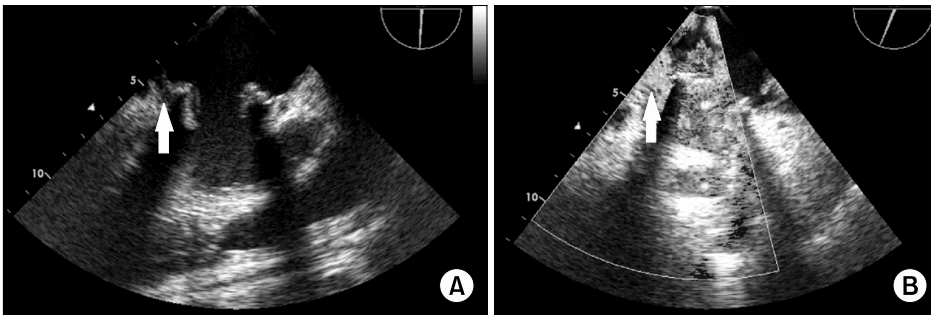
Transesophageal echocardiography shows prosthetic valve dehiscence. (A) 2-D image, (B) Color Doppler image. Arrow shows prosthetic valve dehiscence.
